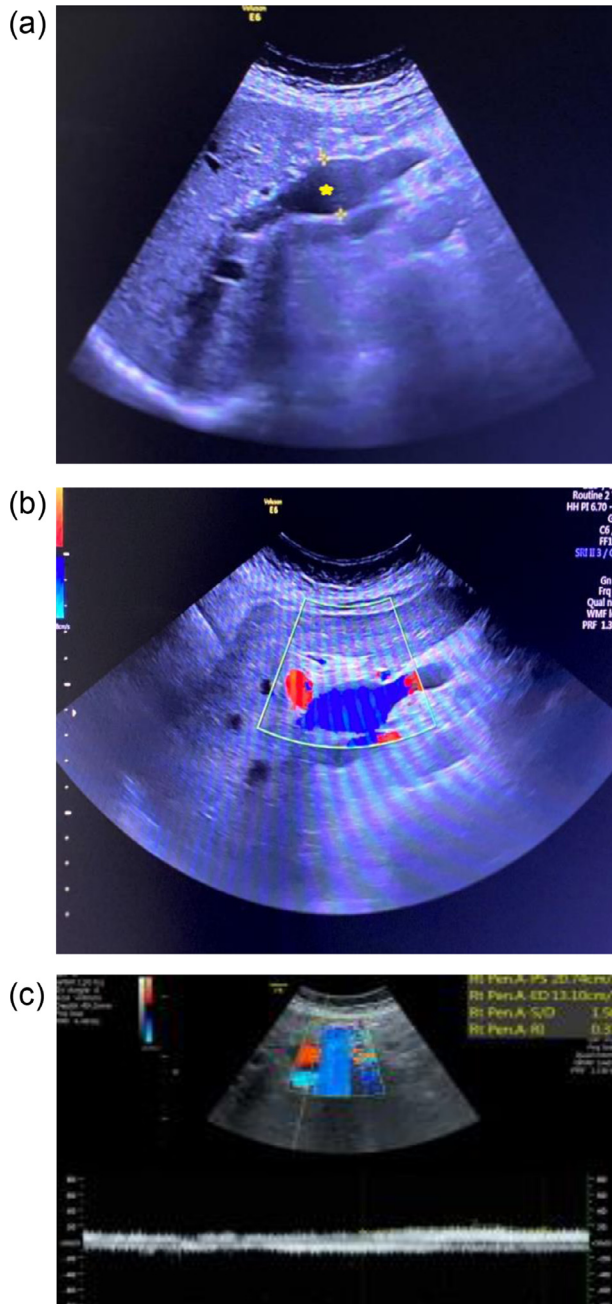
(a) Case 1- Ultrasound abdomen, depicting a focal dilatation of portal vein, measuring 2.5 cm (yellow star). (b) Case 1- Blood flow within the PVA on color Doppler. (c) Case 1- Venous waveform of PVA.
